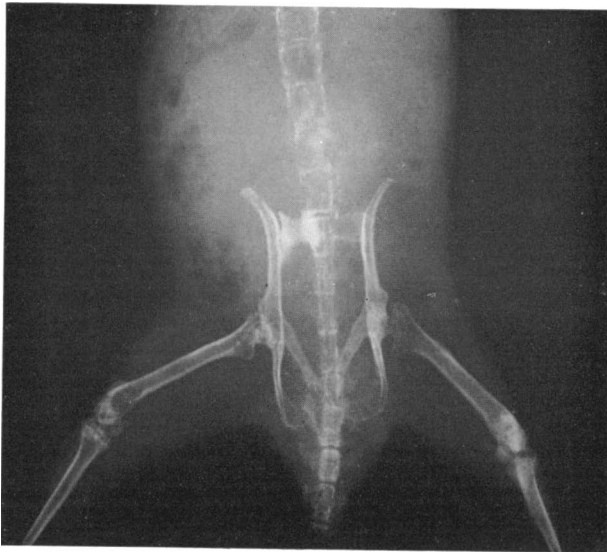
Roentgenogram of a fibroblastic osteosarcoma in the lumbar vertebrae. Note opacity in transverse process of first sacral vertebra.
